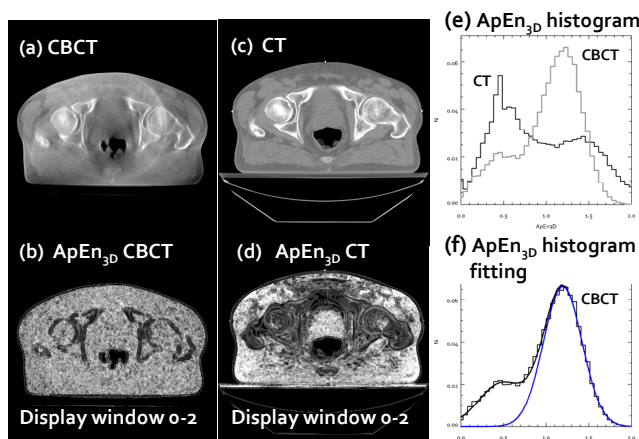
Pelvis CBCT and CT before and after ApEn_{3D} processing.
